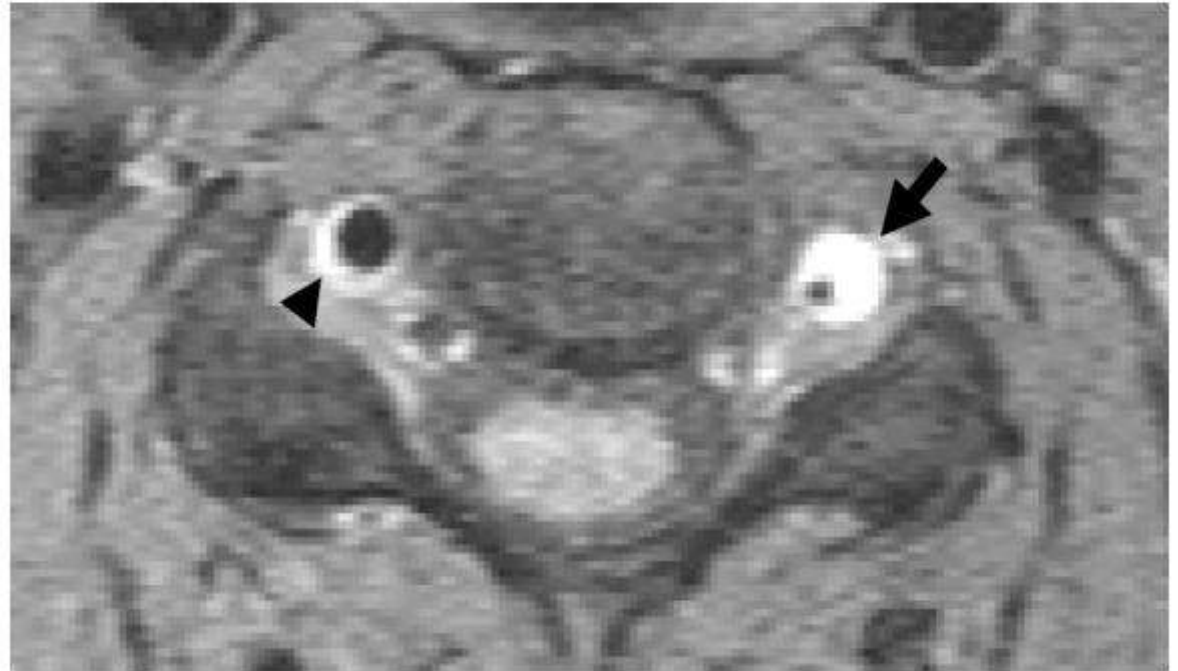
The axial fat-saturated T1 MRI sequence shows dissection of the left (arrow) and dissection of the right VA (arrow head).
